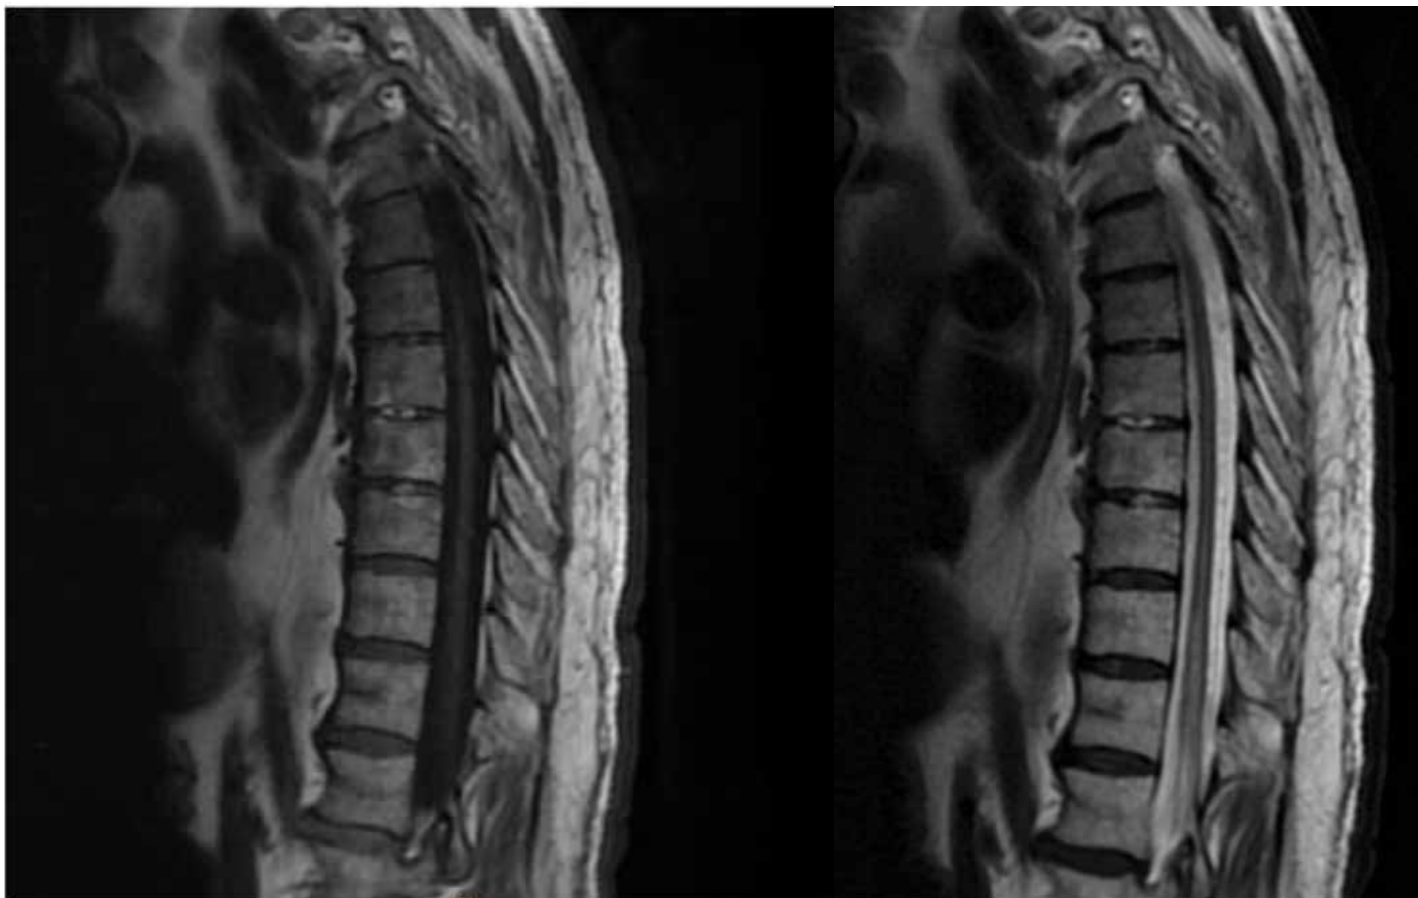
MRI of the Thoracic Spine (Without and With Contrast). High T2 signal intensity is noted in the spinal cord from T8 to the conus, consistent with a spinal cord infarction
